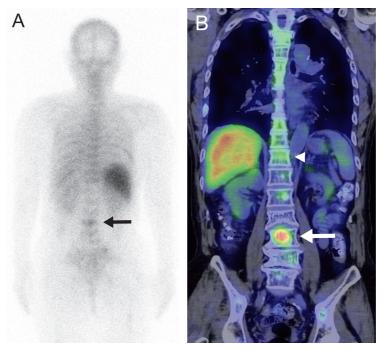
111 Indium chloride (111 In–Cl₃) scintigraphy with single-photon emission computed tomography/computed tomography (SPECT/CT) findings. The posterior planar (A) and SPECT/CT (B coronal) scintigraphy images showing abnormal increase in tracer uptake in the L3 vertebra (arrows) and subtle uptake in the other vertebrae (arrowhead). The 111 In–Cl₃ uptake pattern detected by SPECT/CT was similar to the 16 F–FDG uptake pattern corresponding to the bone lesions on MRI.
